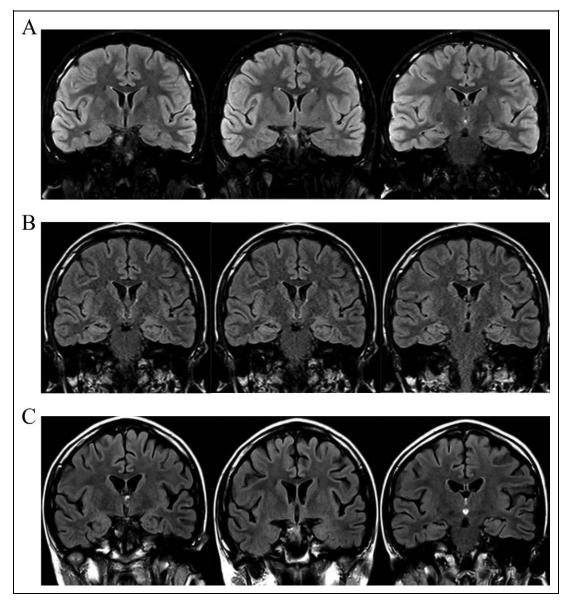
(A) Baseline coronal fluid-attenuated inversion recovery magnetic resonance images (MRIs) taken at the initial phase of the disease demonstrating normal size of hemispheric sulci and lateral ventricles. (B) Coronal fluid-attenuated inversion recovery MRIs show mild dilation of hemispheric sulci and lateral ventricles. (C) Coronal fluid-attenuated inversion recovery MRIs show increased dilation of hemispheric sulci and lateral ventricles compared to previous images.
